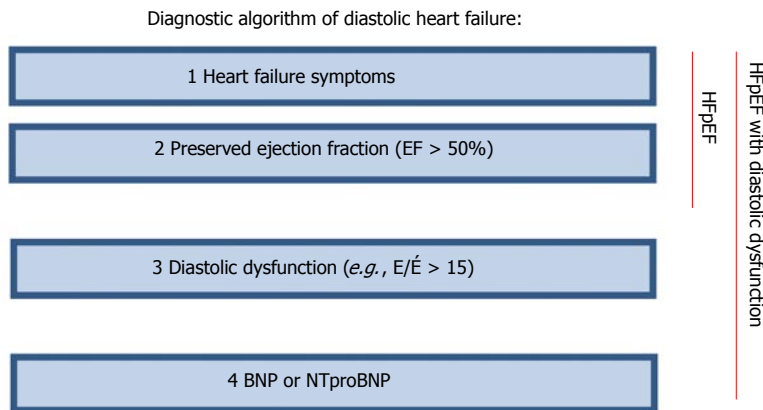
Diagnostic algorithm of diastolic heart failure. BNP: B-type natriuretic peptide; NT-proBNP: N-terminal of the B-type natriuretic peptide; E/Ė: Pulsed-wave Doppler E wave velocity divided by tissue Doppler E wave velocity; HFpEF: Heart failure has preserved left ventricular ejection fraction.
